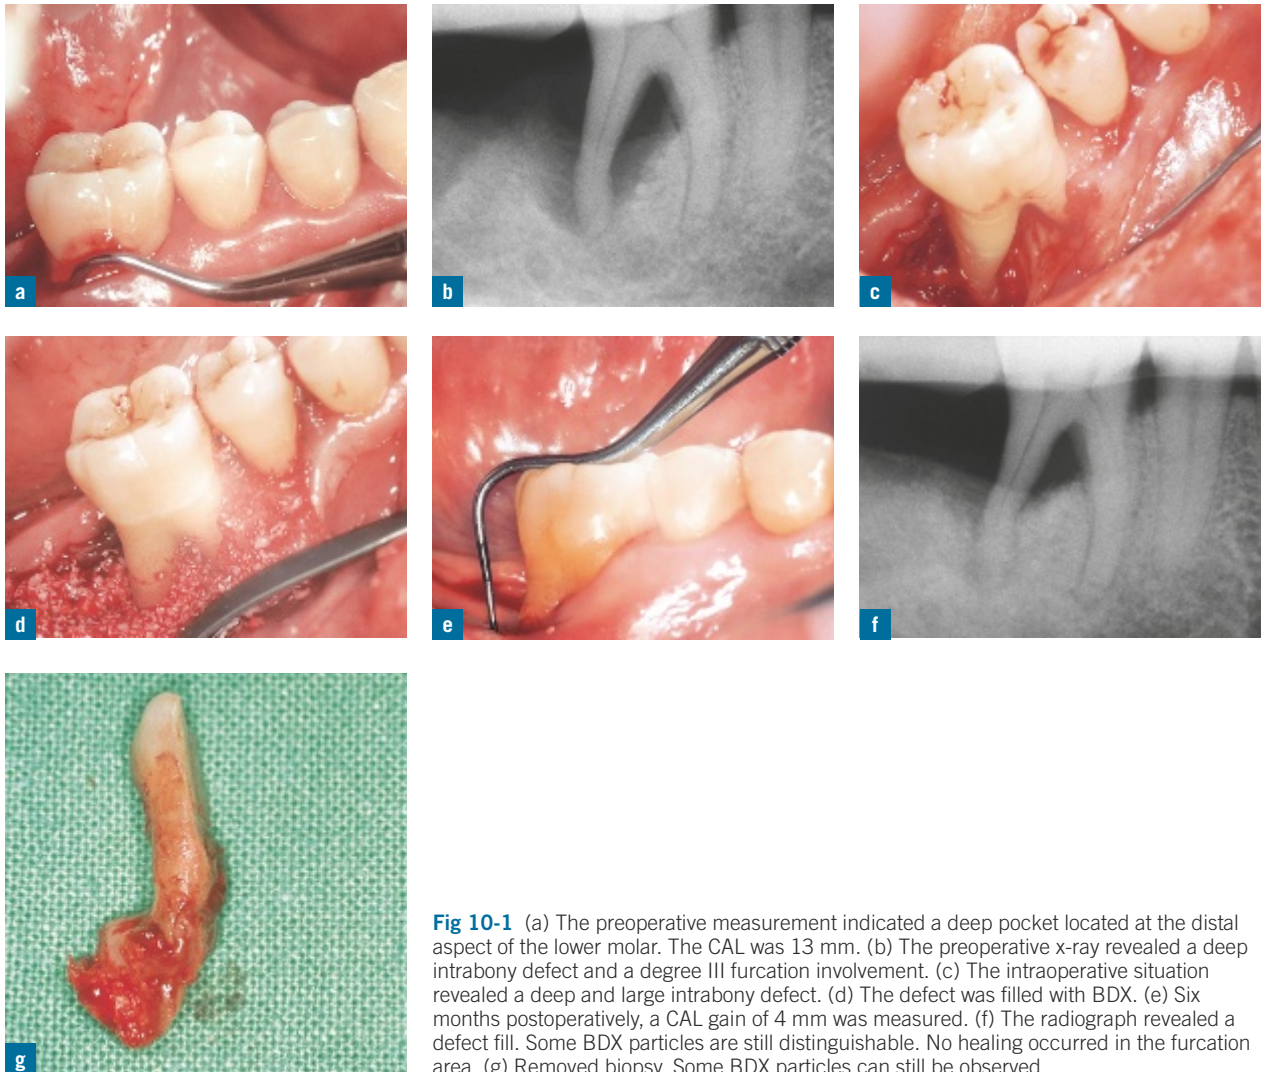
(a) The preoperative measurement indicated a deep pocket located at the distal aspect of the lower molar. The CAL was 13 mm. (b) The preoperative x-ray revealed a deep intrabony defect and a degree III furcation involvement. (c) The intraoperative situation revealed a deep and large intrabony defect. (d) The defect was filled with BDX. (e) Six months postoperatively, a CAL gain of 4 mm was measured. (f) The radiograph revealed a defect fill. Some BDX particles are still distinguishable. No healing occurred in the furcation area. (g) Removed biopsy. Some BDX particles can still be observed.
